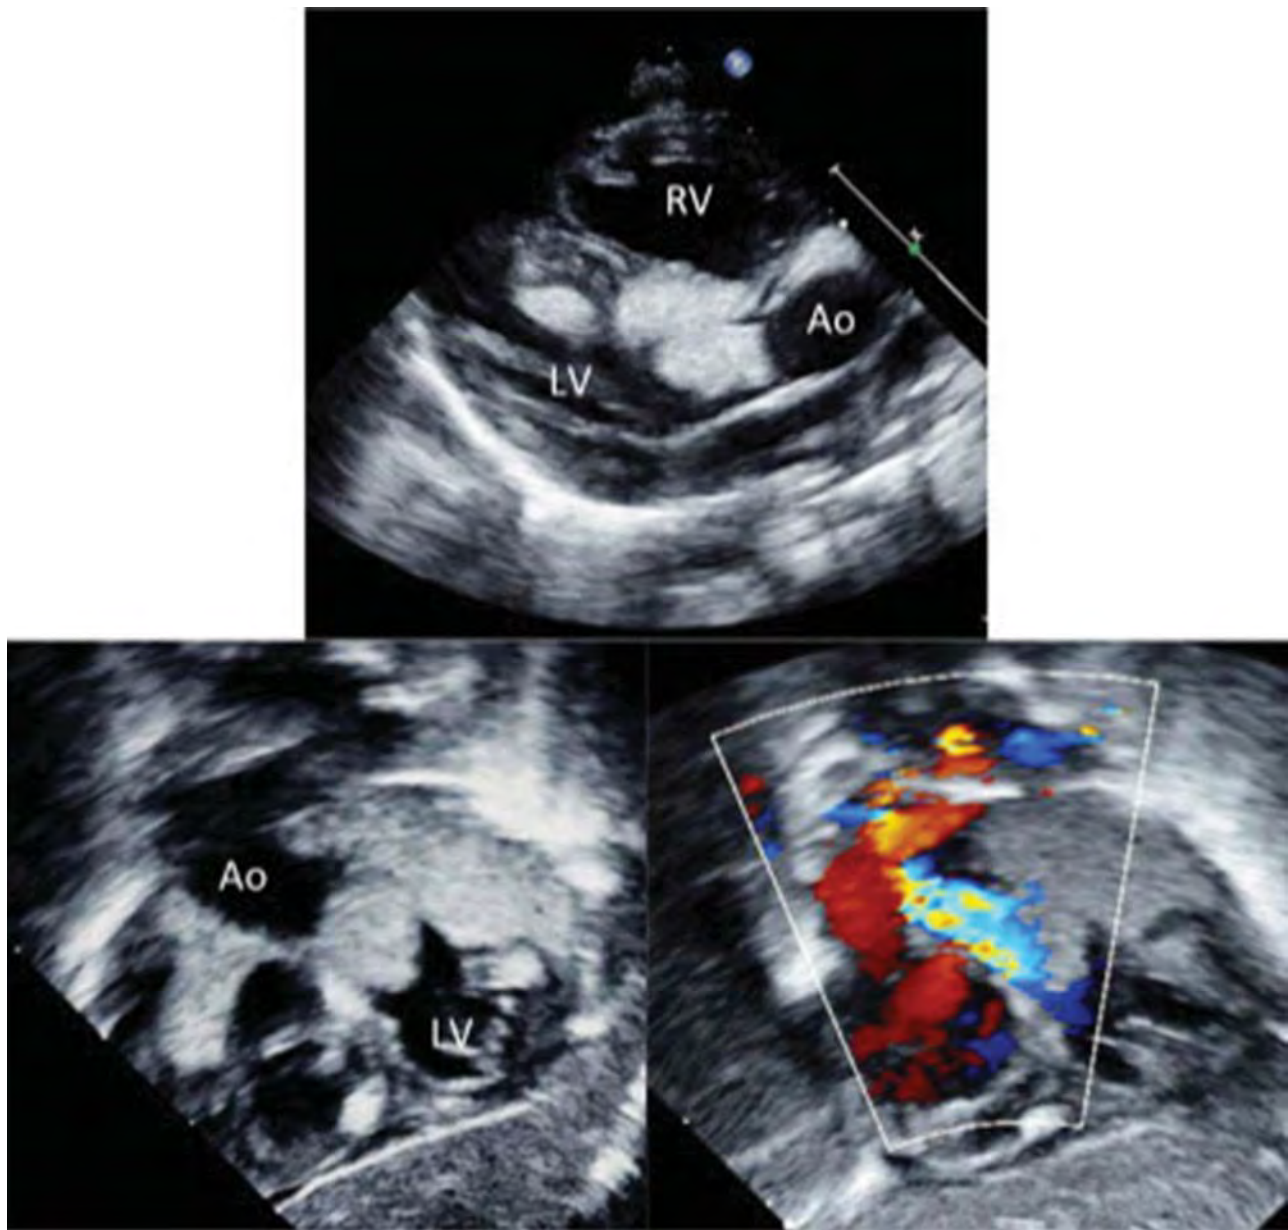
Multiple cardiac rhabdomyomas in a neonate with tuberous sclerosis. Though rarely obstructive, in this particular case there was moderate obstruction to the left ventricular outflow tract seen by color Doppler from the subcostal coronal image (lower right). These tumors can be detected in the mid-gestation fetus, and often enlarge at an alarming rate through the remainder of gestation, but will regress postnatally.
